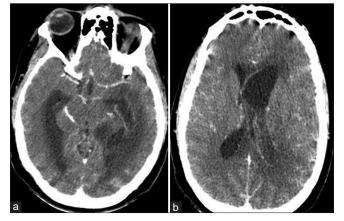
(a and b) Computed tomography scan of the brain showed a lesion in the left lateral ventricle with minimal, fine, and complete rim enhancement. There was an enlargement of the left lateral ventricle with an isodense lesion, suggesting an intraventricular collection.
